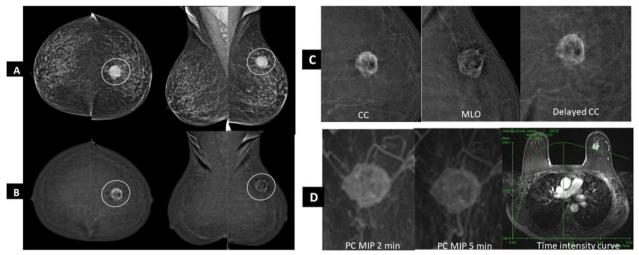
Images of a 54-year-old lady with a left breast lump. A Low energy images of both breasts in craniocaudal (CC) and mediolateral oblique (MLO) projections show a round mass with circumscribed margins in the upper central quadrant of the left breast (marked by white circle). B Postcontrast recombined images of both breasts show heterogeneous enhancement of the right breast mass with high conspicuity. C Postcontrast recombined images of the mass show high density of the lesion in CC image at 2 min with reduction in density in MLO (4 min) and delayed (8 min) views suggestive of type 3 kinetics. D Postcontrast subtraction maximum intensity projection (MIP) MR images at 2 min and at 5 min show early intense enhancement with washout at 5 min—consistent with type 3 (washout) kinetics. Time intensity curve confirms the same. Biopsy was invasive ductal carcinoma
